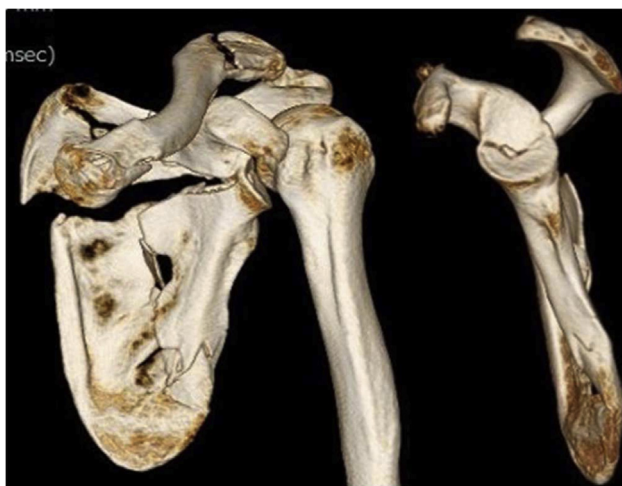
Primary CT showing a left Ideberg type V scapular fracture, left proximal and distal clavicle fractures with the disruption of the SSSC, and floating shoulder. CT, computed tomography; SSSC, superior shoulder suspensory complex.
